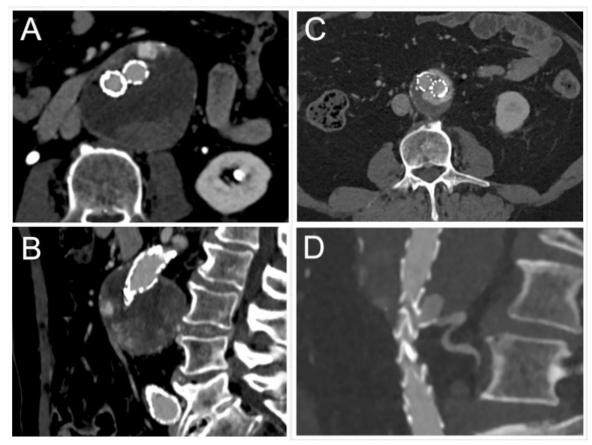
CT scan images showing a Type II endoleak in the aneurysm sac (A, C); example of inferior mesenteric artery (B) and lumbar artery (D) giving rise to the endoleak.
